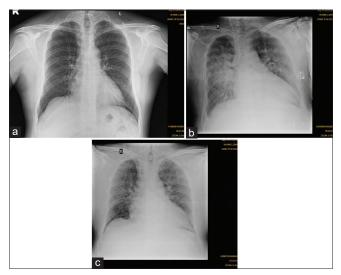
(a) Chest X-ray pre-operative: normal PA film prior to transplantation. (b) Chest X-ray Day 4 post-transplantation: AP view showing bilateral diffuse infiltrates with perihilar prominence. (c) Chest x-ray post-operative day 6 with the resolution of infiltrates
